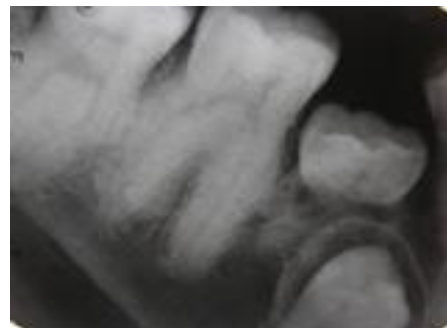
Periapical view revealed pulp stone.
